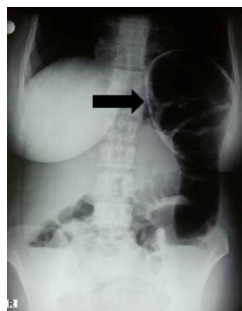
Arrow shows megacolon on plain abdominal radiograph (postoperative day 1).
